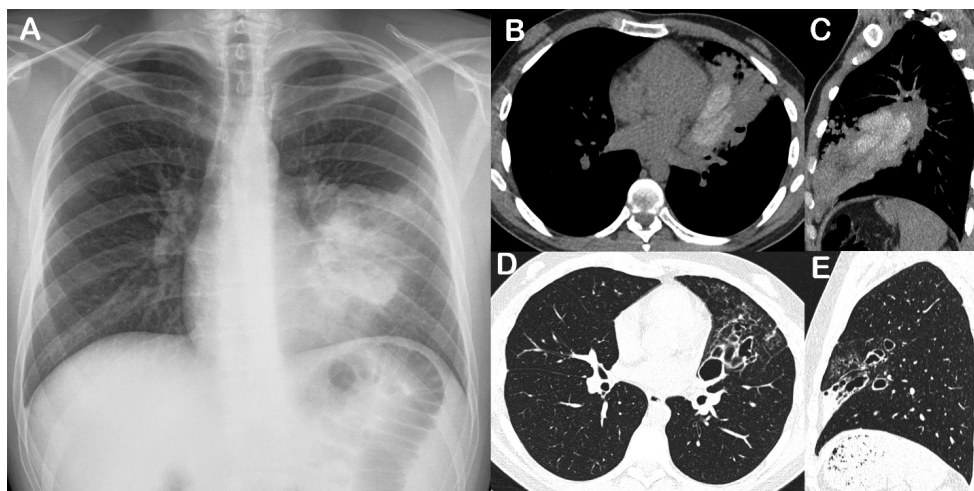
(A): Posteroanterior chest radiograph demonstrating heterogeneous opacity in the left lung. Chest CT images with axial (B) and sagittal (C) reconstruction showing heterogeneous consolidation in the lingula, with branching tubular opacities corresponding to areas of high-attenuation mucoid impaction inside dilated bronchi. (D, E) Follow-up CT images obtained 6 months later showing bronchiectasis persistence and resolution of the hyperdense mucous impaction.
